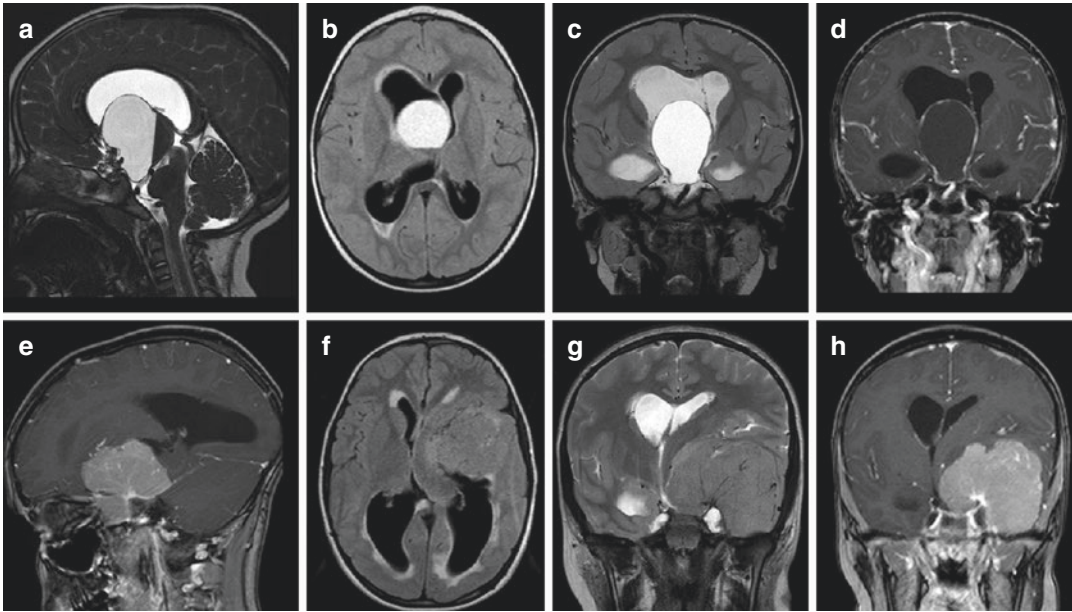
Hydrocephalus due to external compression of ventricular system. (a–d) Midsagittal T2-weighted DRIVE, axial FLAIR-weighted, coronal T2-weighted, and gadolinium-enhanced T1-weighted MR images show suprasellar neoplastic masses with massive cystic component and fluid level, causing obliteration of third ventricle and asymmetric obstruction of foramen of Monro with prevalent dilation of the right ventricle. (e–h)
